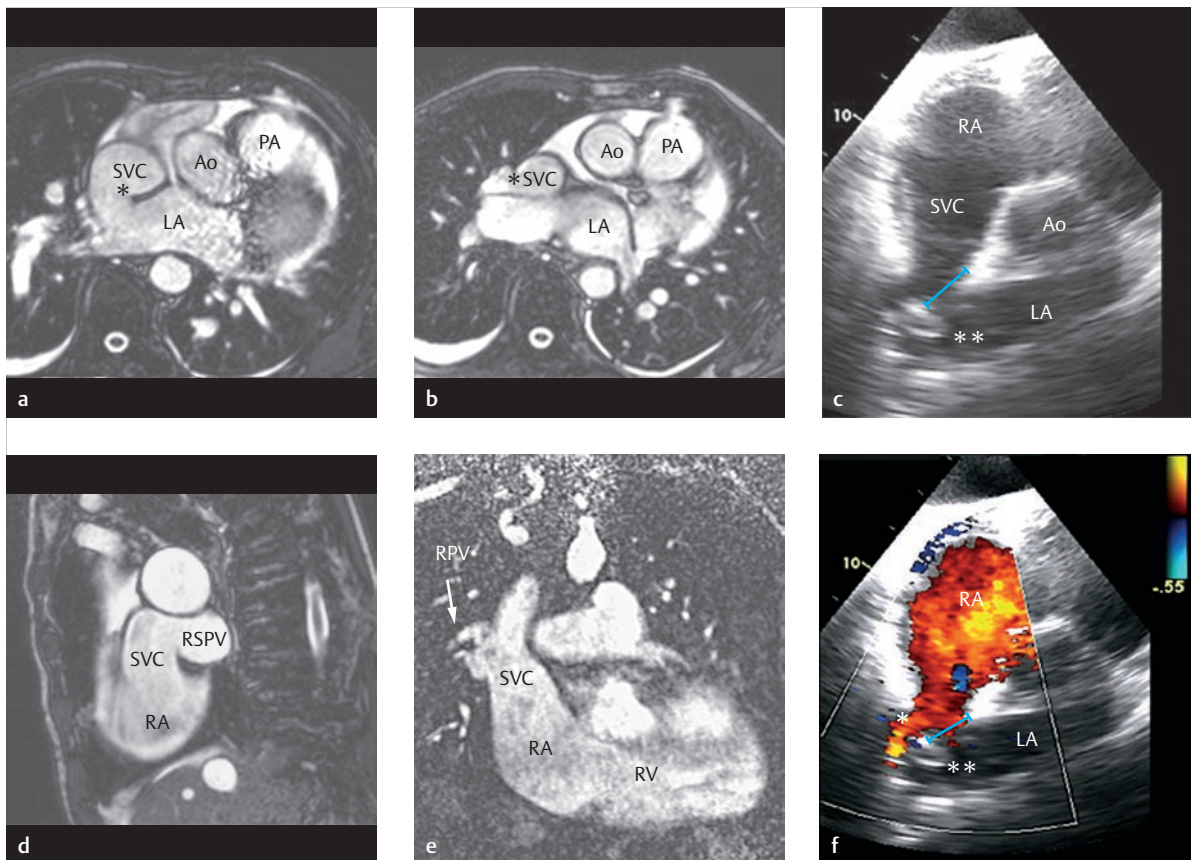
Superior SVD with partial anomalous connection of the right pulmonary vein to the superior vena cava and right atrium. This is the same patient as in ► Fig. 4.132 and ► Fig. 4.134. 2-D echocardiography (c, f) depicts both the anomalous connection of the right pulmonary vein (asterisk) and ordinary connection of a right pulmonary vein to the left atrium (double asterisk), as well as the interatrial communication (IAC = blue line) according to Moss.¹⁶⁷
